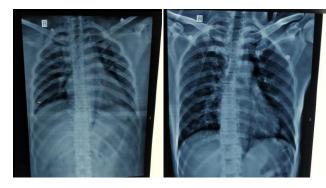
Chest X-ray views of two styrene gas poisoning victims.
